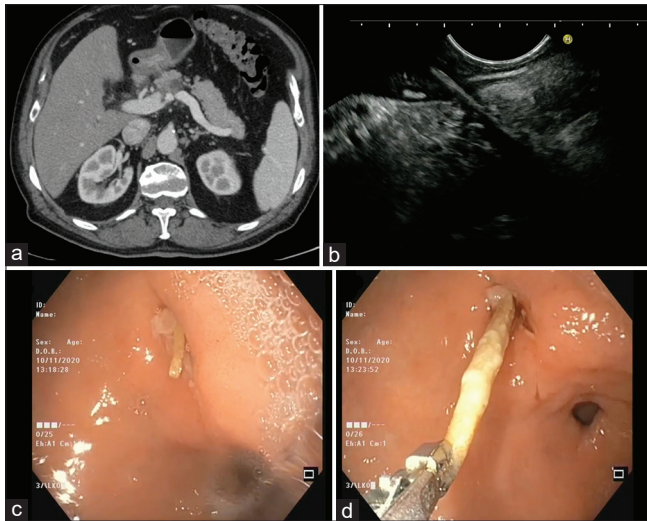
(a) Venous phase of computed tomography scan with evidence of a pancreatic hypovascular mass with portal vein lumen obliteration; (b) EUS detection of a linear hyperechoic image extending from gastric wall to the pancreatic neck; (c) endoscopic appearance of a sharp penetrating foreign body; (d) toothpick endoscopically removed by forceps
